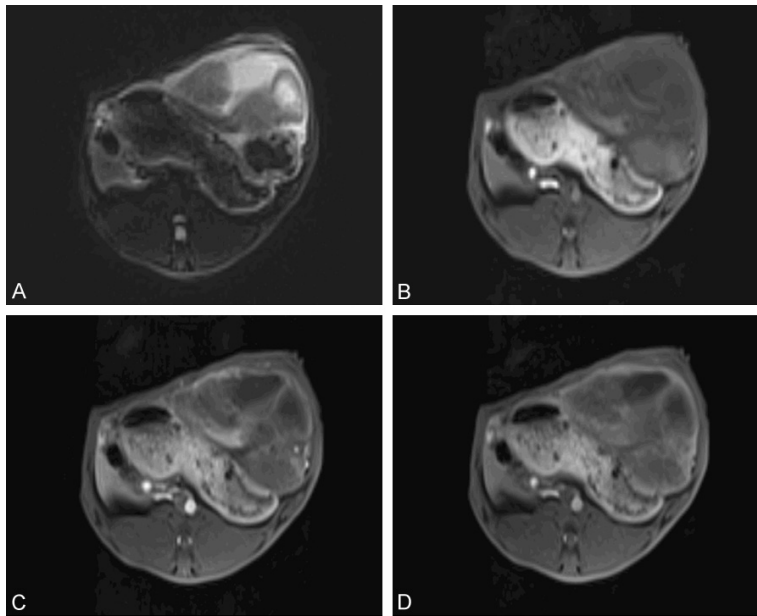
MRI detection of VX2 hepatocarcinoma with celiac implantation. (A) T2-weighted images and (B) T1-weighted images: celiac implantation. (C) T1-weighted enhanced images at the arterial phase: marked enhancement demonstrated that VX2 hepatocarcinoma implanted in celiac. (D) T1-weighted enhanced images at the delayed phase: mild enhancement revealed that VX2 tumor in celiac had less blood supplying than other implantation site.
